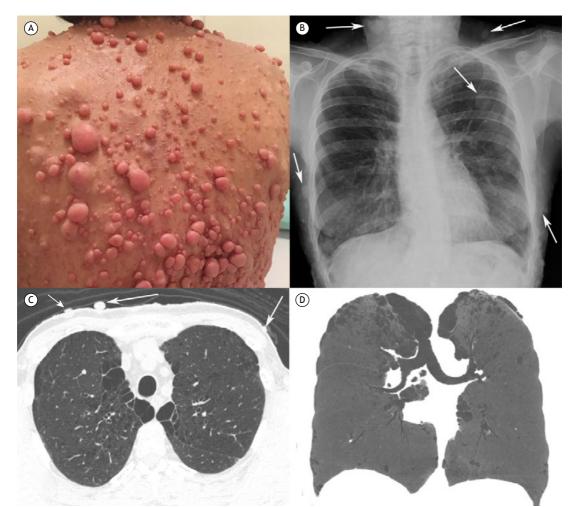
In A, a photograph of the dorsal region of the chest showing multiple cutaneous neurofibromas. In B, a chest X-ray shows multiple soft-tissue nodules on the chest wall (arrows). In C and D, respectively, an axial chest CT image (lung window) at the level of the upper lobes and a coronal minimum intensity projection image show emphysematous lesions predominantly in the upper lobes. Note also nodules (neurofibromas) on the chest wall (arrows in C).
